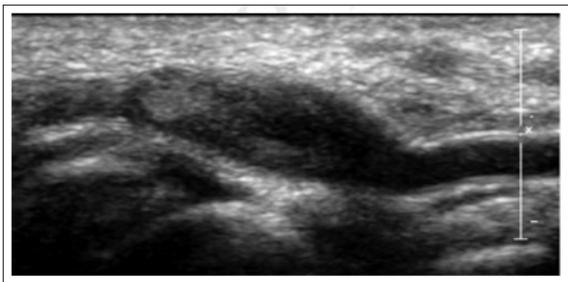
Doppler Ultrasound Showing Saccular Pseudoaneurysm with Preserved Arterial Wall Layers
